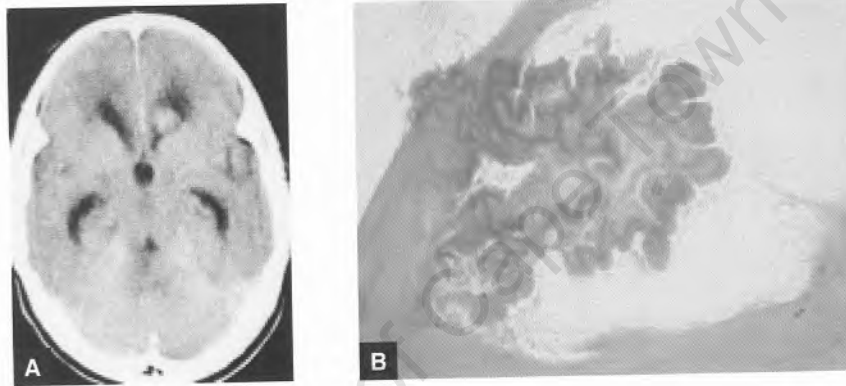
Axial CT scan showing enhancing lesion in left frontal horn (a); stereotactic biopsy was non-diagnostic, showing normal brain and choroid plexus (b).
